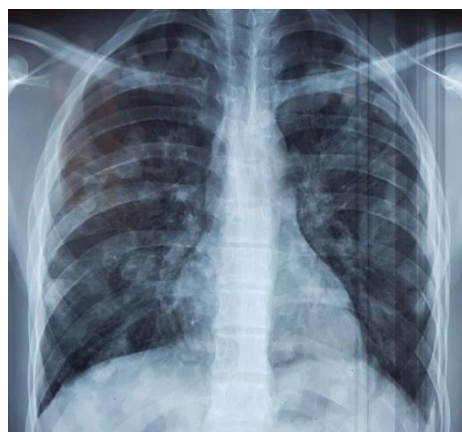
Chest radiograph. Bilateral nodular opacities showing balloon release
